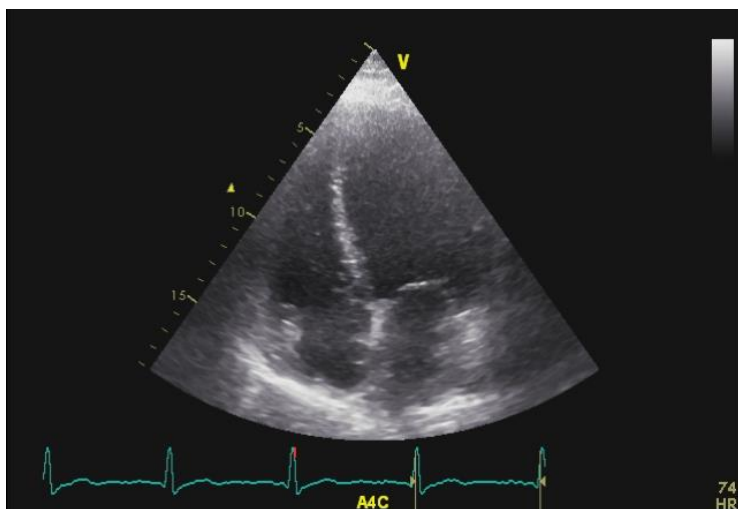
Apical 4 chamber some months after left sided mastectomy. The lateral LV wall (upper right part of the image) is not visible
